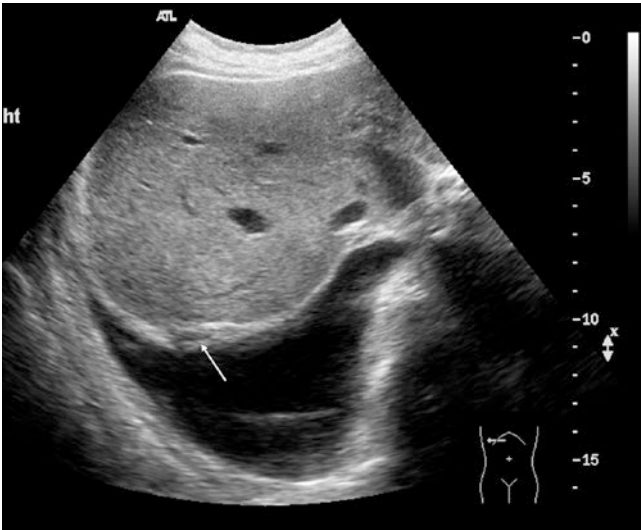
a Smoothly demarcated opacification at the diaphragm in chest-X-ray, incidental finding. In retrospect this lesion was already guessed on a previous chest-X-ray 7 years earlier. b By ultrasound a cyst-like lesion with solid parts and septae seeming to originate from the diaphragmatic pleura. No calcifications, with color-Doppler no vessels detectable. c By CEUS in the bronchial-arterial phase the solid
